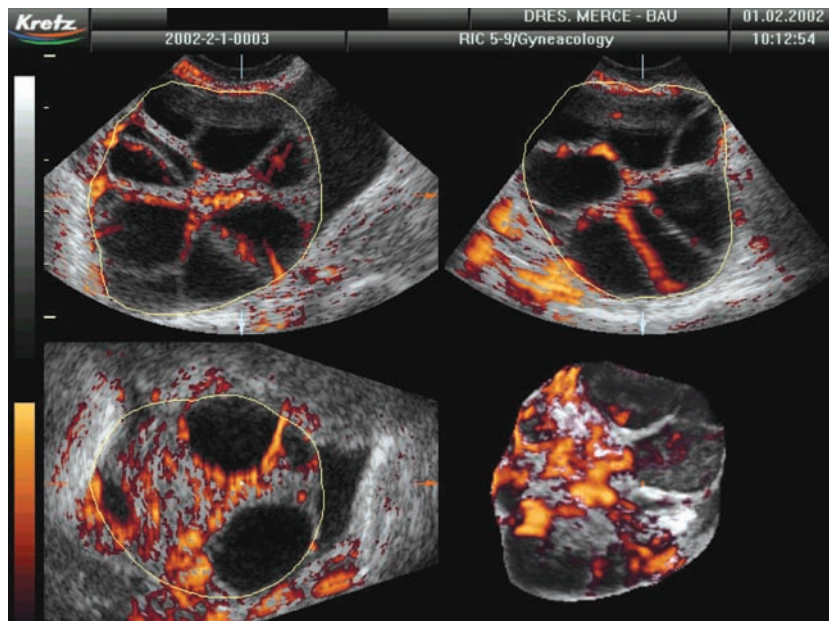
Three-dimensional power Doppler angiography rendering of the perifollicular vasculature in an IVF cycle at the day of hCG administration.
